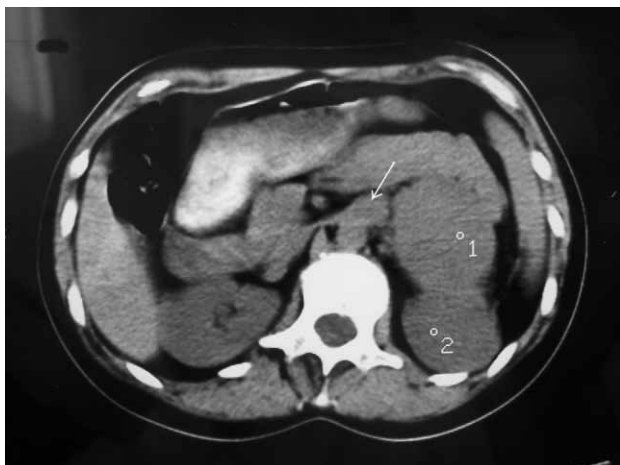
Computer tomography (CT) scan. Large left adrenal tumor (1) with the arrow pointing on the tumor thrombus and the kidney (2).
